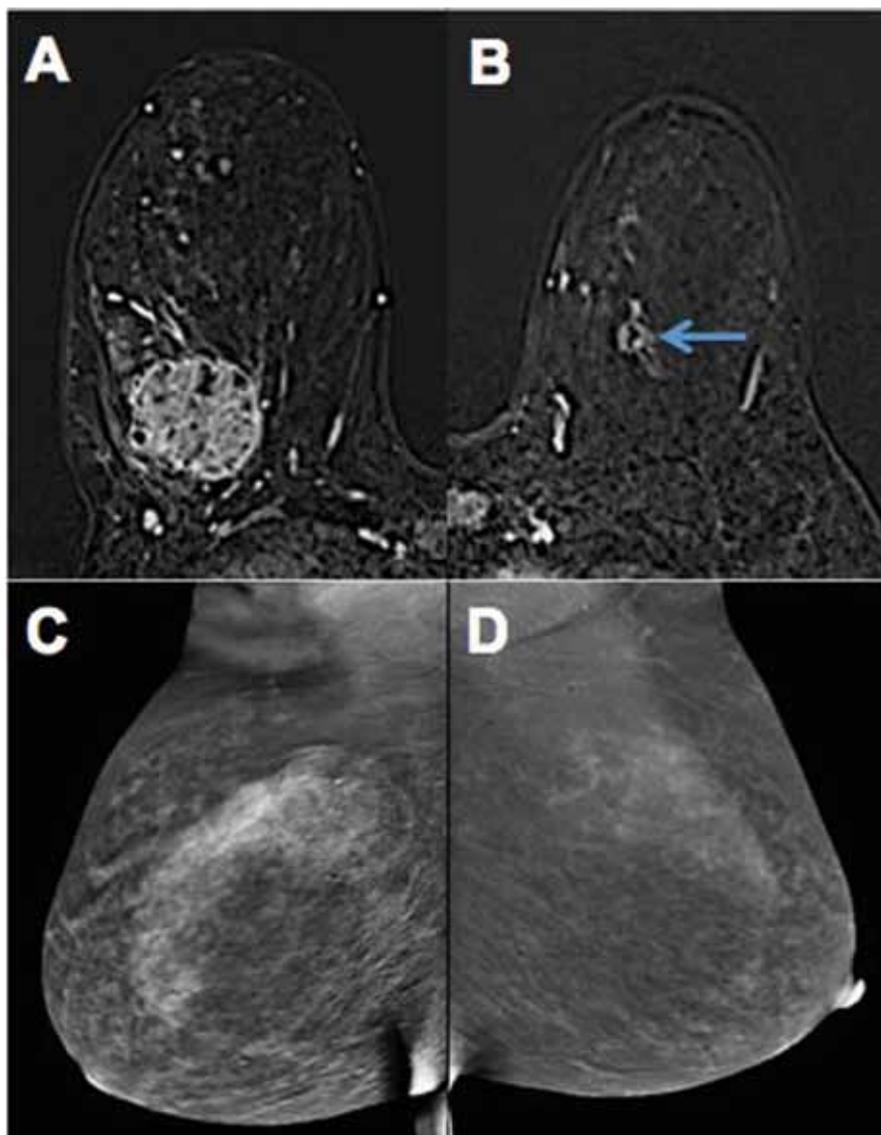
A 46 year-old woman presented with a right breast palpable abnormality at the 9:00 position. After diagnostic mammography and breast ultrasound showed a suspicious 4.5 cm mass at the 9:00 position of the right breast (not shown), ultrasound-guided core needle biopsy yielded invasive carcinoma of no special type. Contrast-enhanced breast MRI showed the biopsy-proven cancer at the 9:00 position of the right breast (A), as well as a rim-enhancing mass at the 11:00 position of the left breast (arrow, B) without correlate on CESH (C, D) or targeted second look breast ultrasound. MRI-guided biopsy yielded fibrocystic change.
